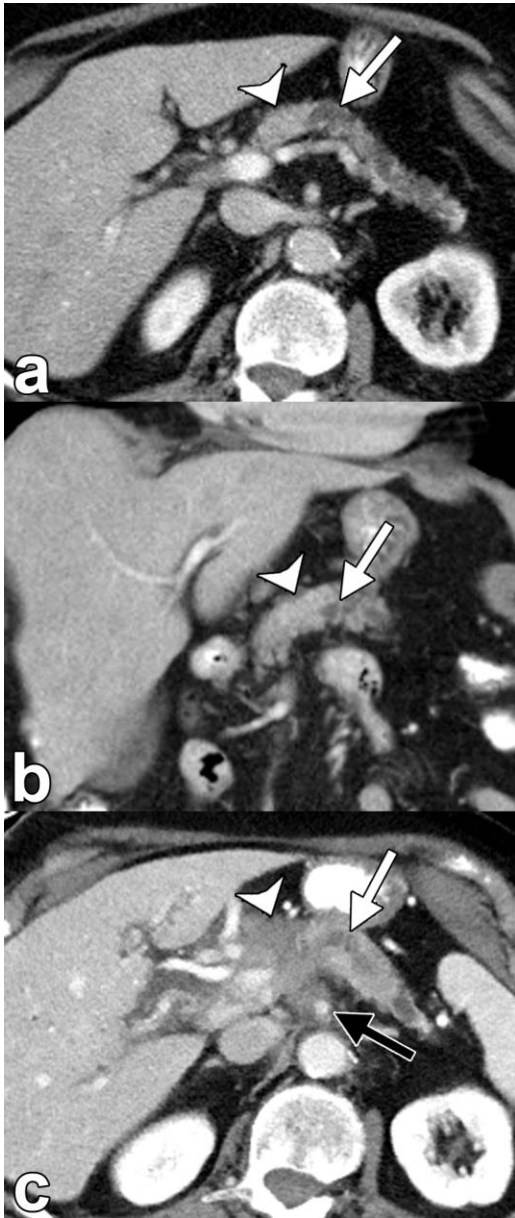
Example of a false negative CT examination. A 73 year-old woman presented to the Emergency department underwent uniphasic contrast-enhanced CT to evaluate vague abdominal tenderness and nausea. (a) Axial and (b) coronal images show sparing of atrophy in the pancreatic neck, with no contour deformity or altered attenuation (arrowheads). Upstream to this region, the pancreatic body and tail are atrophic and the main pancreatic duct is dilated (white arrows) with abrupt cutoff. Imaging findings were interpreted as a probable structure secondary to pancreatitis. (c) Axial contrast-enhanced CT was performed over 1 year later for right upper quadrant pain shows an ill-defined mass arising from the pancreatic neck (arrowhead), with worsening duct dilation (white arrow) and invasion of the superior mesenteric artery (black arrow).
